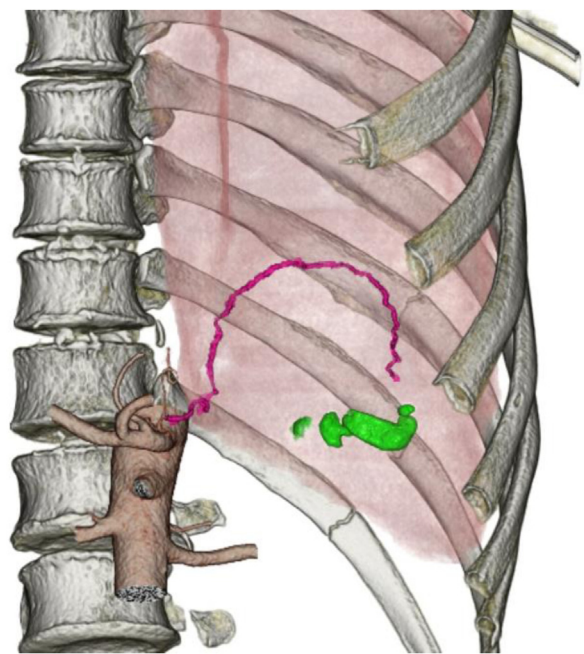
CT angiography showed a contrast agent leak originating from the right inferior phrenic artery.
